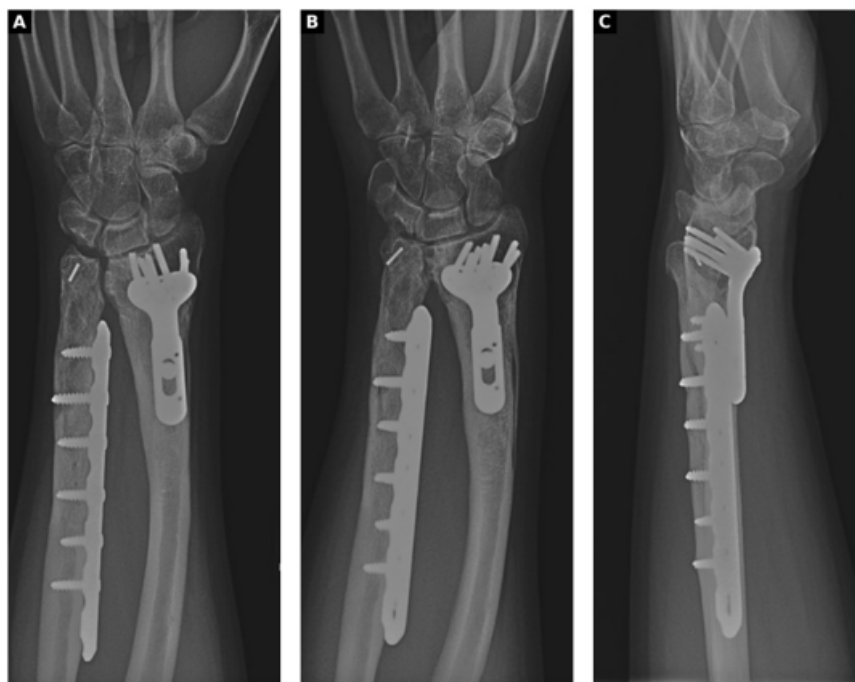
Two-year follow-up radiographs. (A–C) AP, oblique, and lateral views showing a healed radial osteotomy, incorporated ulnar allograft, maintained fixation, and no recurrence of synostosis.
